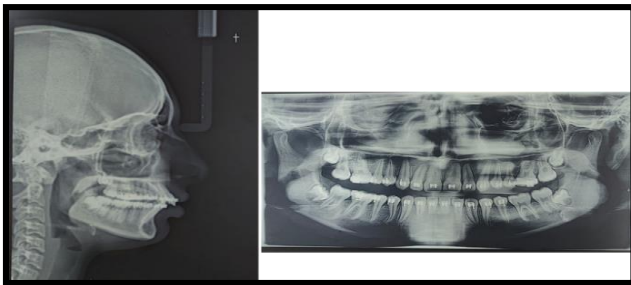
Pre-forsus x-rays (a) Lateral cephalogram (b) OPG
